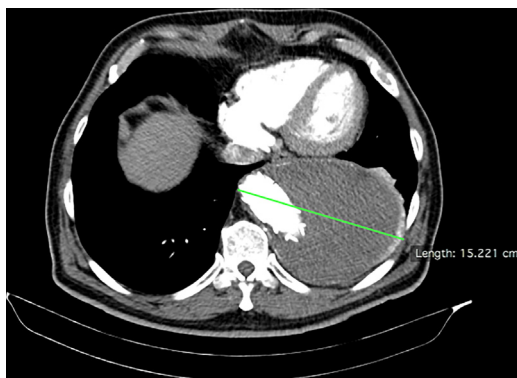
CT angiogram at a four-month follow up. The endoprosthesis is well positioned with no endoleaks.
